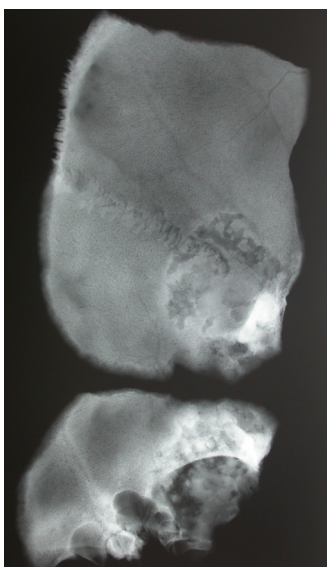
radiograph showing neoplastic involvement of the cranium of HC084.
